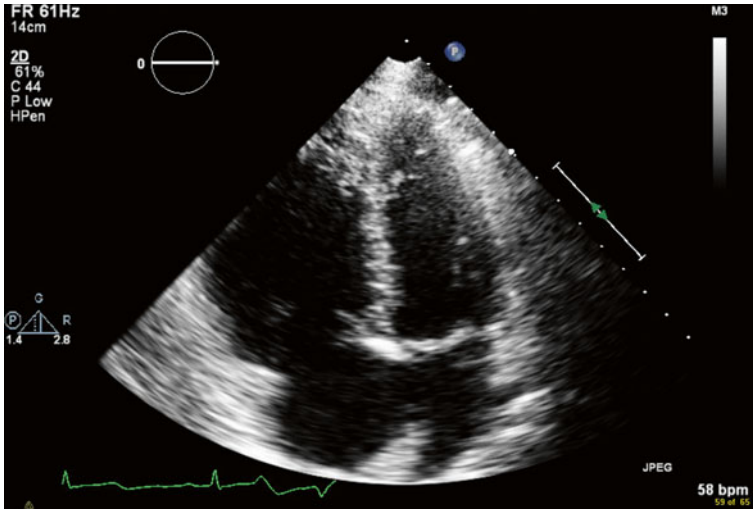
Echocardiography demonstrating right atrial and right ventricular enlargement
